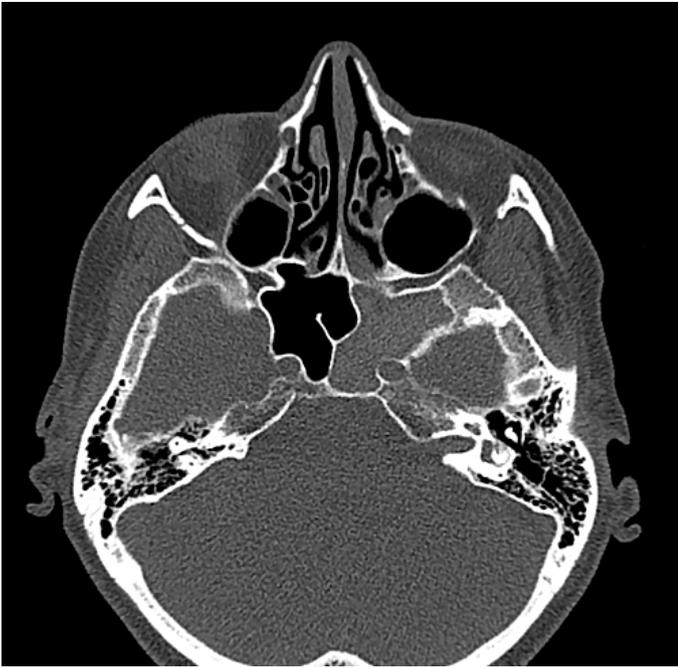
Unenhanced computed tomography scan, axial view, performed one year before surgery. Complete opacification of the left sphenoid sinus without bone erosions of sphenoid sinus walls is apparent.
